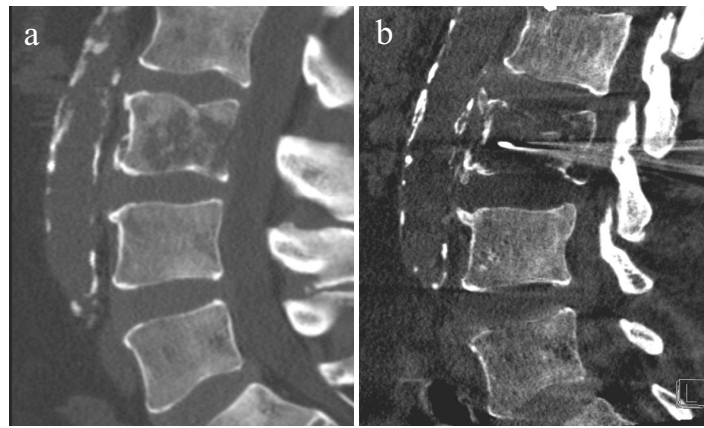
Comparison of the image quality between conventional CT (a) and intra-interventionally acquired FP-CT (Dyna-CT) images (b) of the lumbar spine. Overall, weaker image contrast due to low-dose protocols and artifacts like beam hardening at cortical bone structures or metal artifacts from inserted applicators aggravate precise metastasis localisation and puncture.
